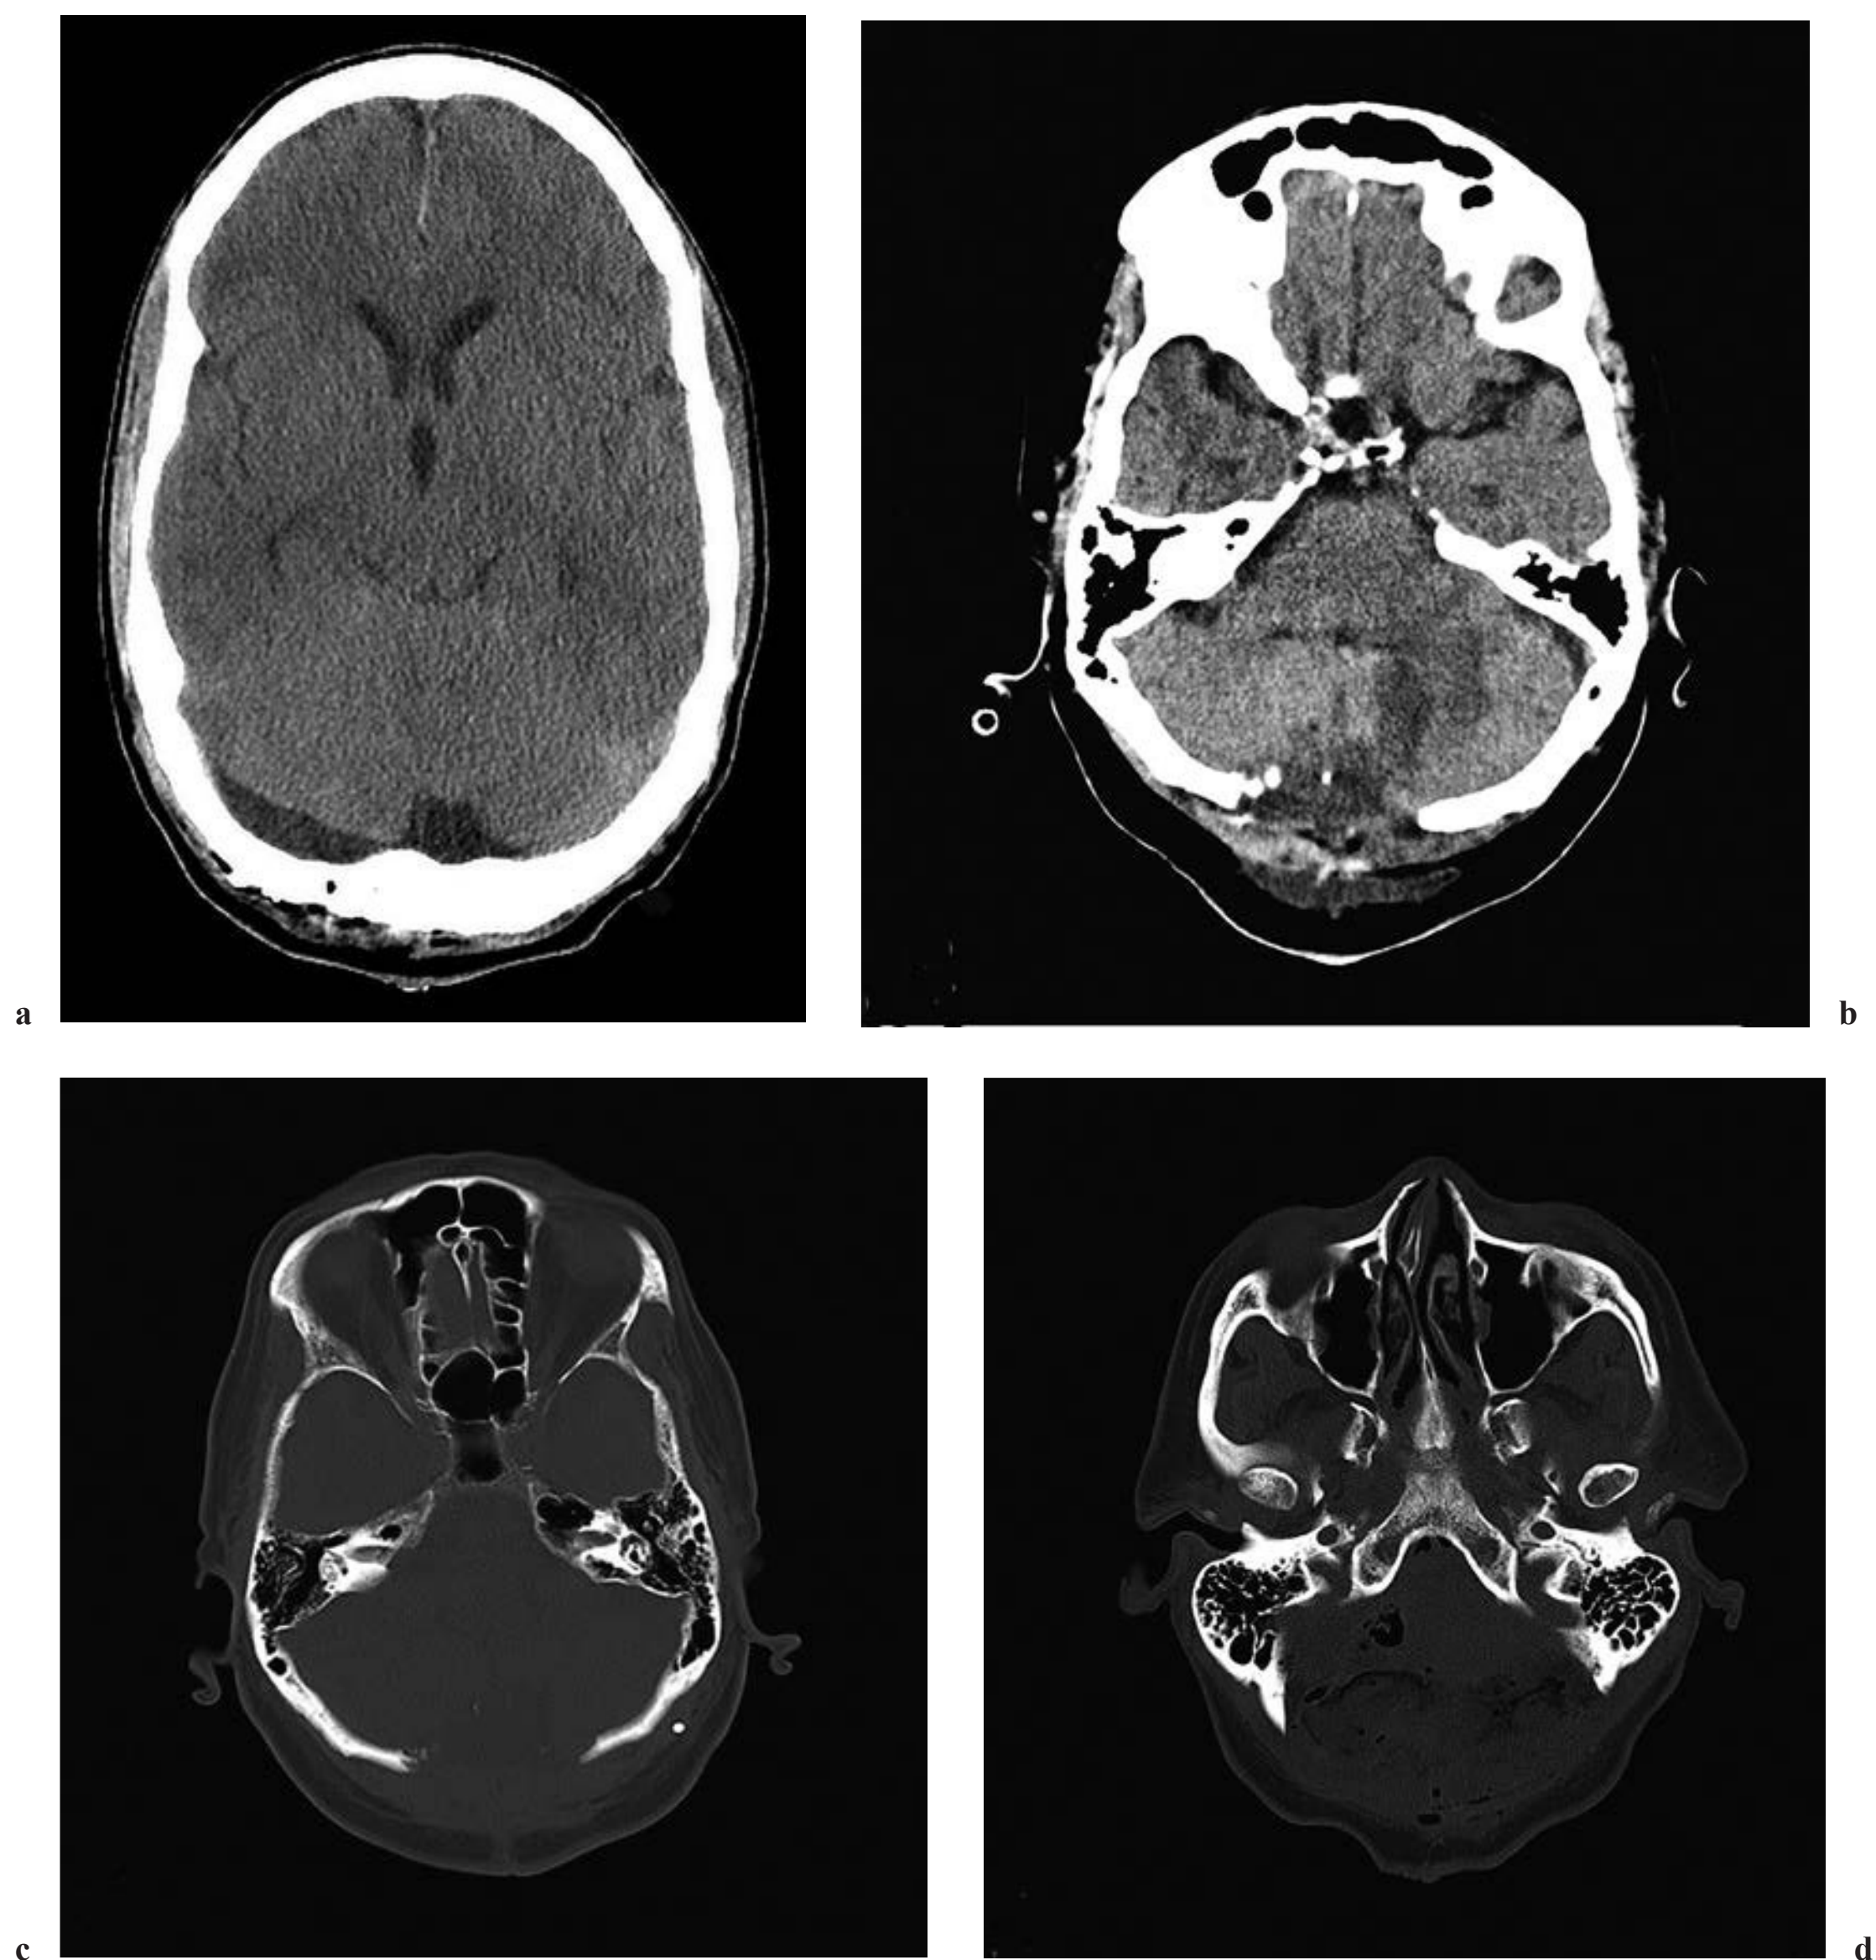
d (a) Axial CT image demonstrating resolution of hydrocephalus following evacuation of a posterior fossa epidural hematoma. (b) Axial CT soft tissue and (c) bone windows demonstrating a tailored approach for evacuation of an intracerebellar hematoma. (d) Axial CT bone window demonstrating the bony margins of a wide suboccipital craniectomy for decompression in the setting of ischemic stroke.
